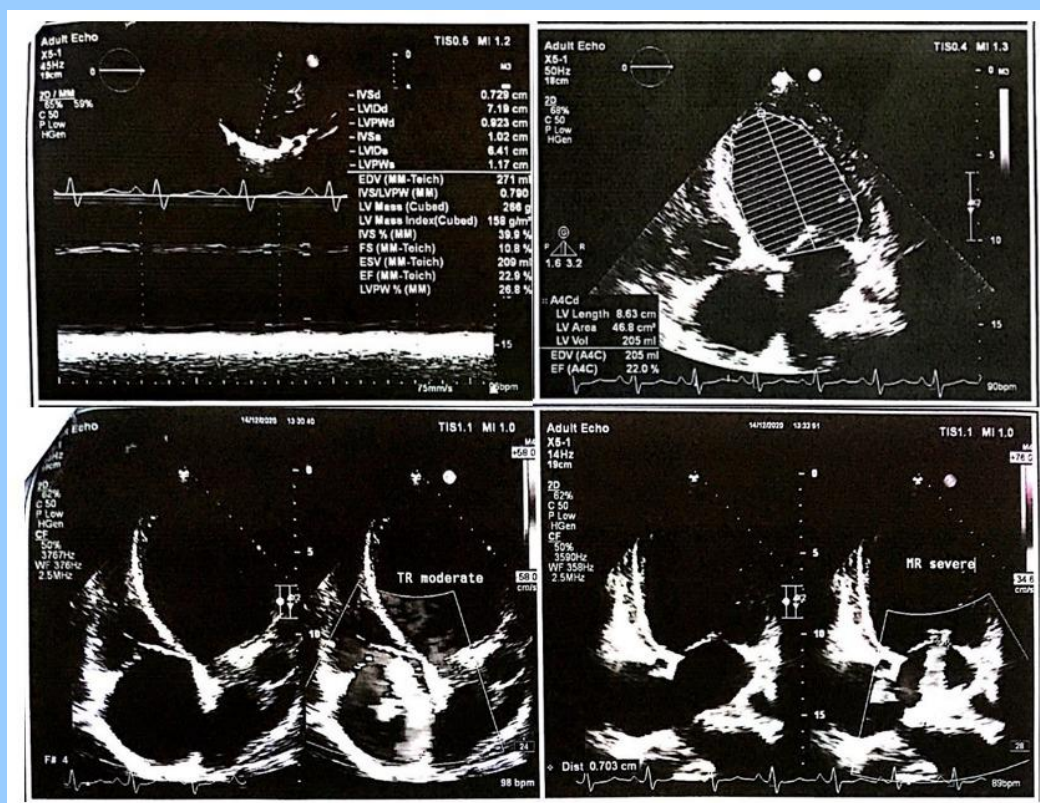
Echocardiography findings
